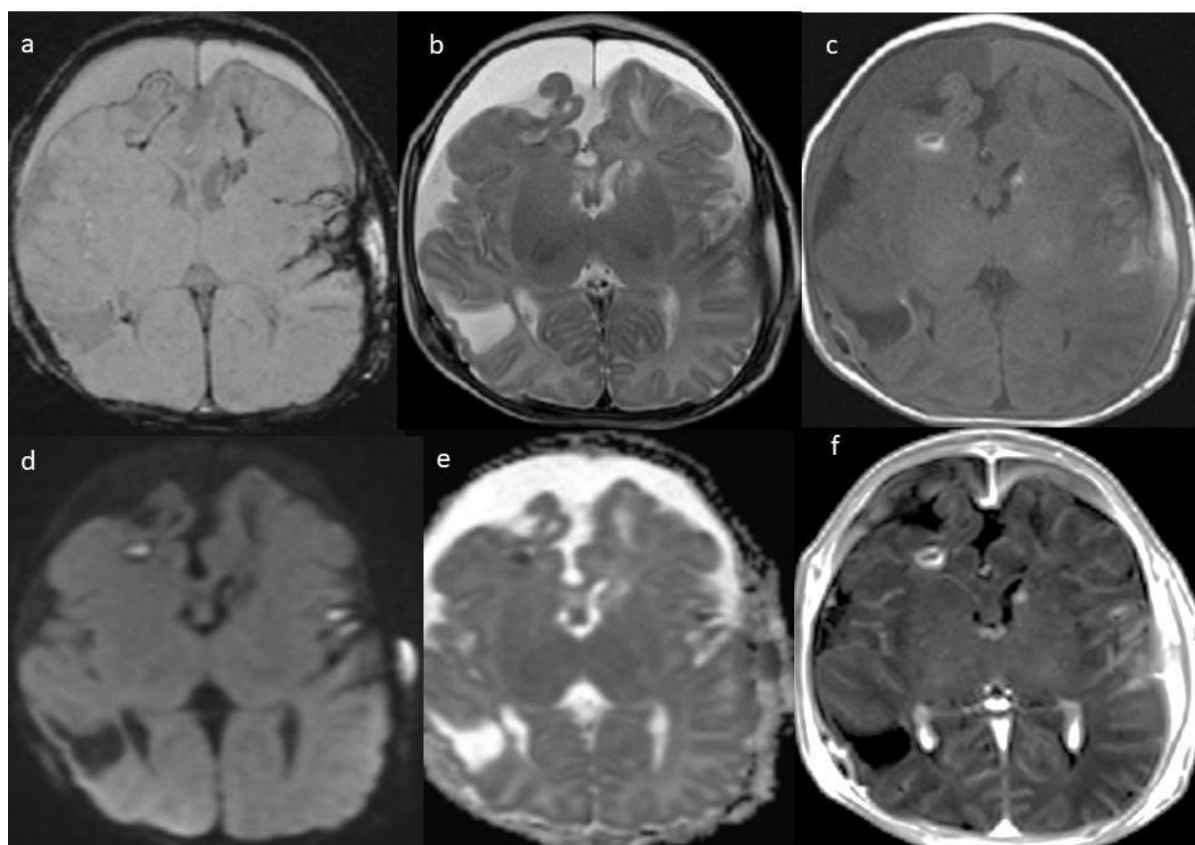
Post-operative MRI (a. GRE/T2*WI, b. FSE/T2WI, c. SE/T1WI, d. DWI, e. ADC map, f. SE/T1WI post-contrast) in roughly corresponding sections demonstrated improvement after the surgical procedures.
